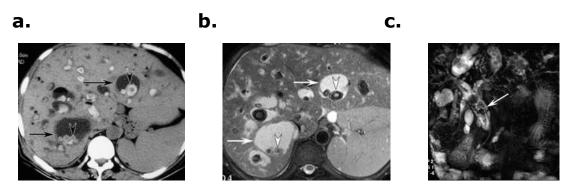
Caroli disease. (a) Unenhanced CT scan shows multiple stones (arrowheads) within dilated bile ducts (arrows). (b) Axial T2-weighted MR image shows multiple hyperintense cystic ectasias (arrows) and calculi (arrowheads). (c) Coronal MR cholangiogram shows multiple dilated bile ducts with calculi. Multiple stones are seen within the dilated common bile duct (arrow). The cystic dilatations communicate with the major biliary tree.
